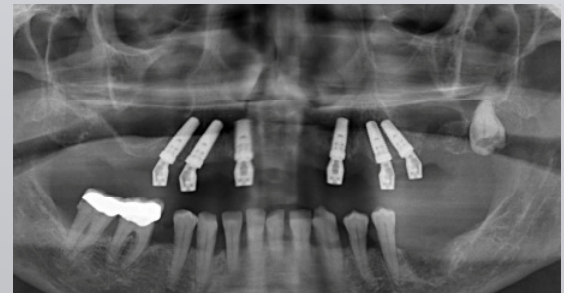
Orthopantomogram taken after implantation
